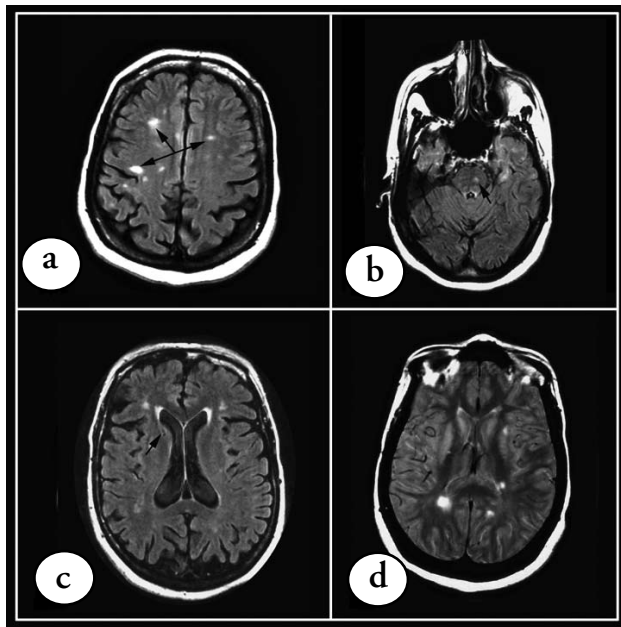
Brain MRI a) fluid-attenuated inversion recovery (FLAIR) showing multiple foci of white matter hyperintensity (arrows) b) FLAIR sequence showing brain stem hyperintense lesions (arrow). c) FLAIR sequence showing low signal intensity-black holes (arrow) and diffuse brain atrophy. d) The white matter foci in Proton density sequence.
